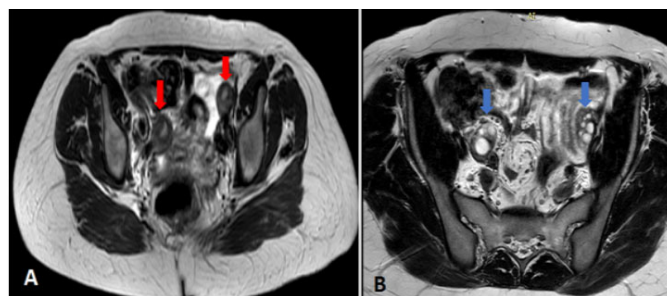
Pelvic MRI in T2-weighted axial plane showing in (A) two distinct rudimentary uterine horns with functional endometrium (red arrows) and in (B) normal ovaries (blue arrows).
